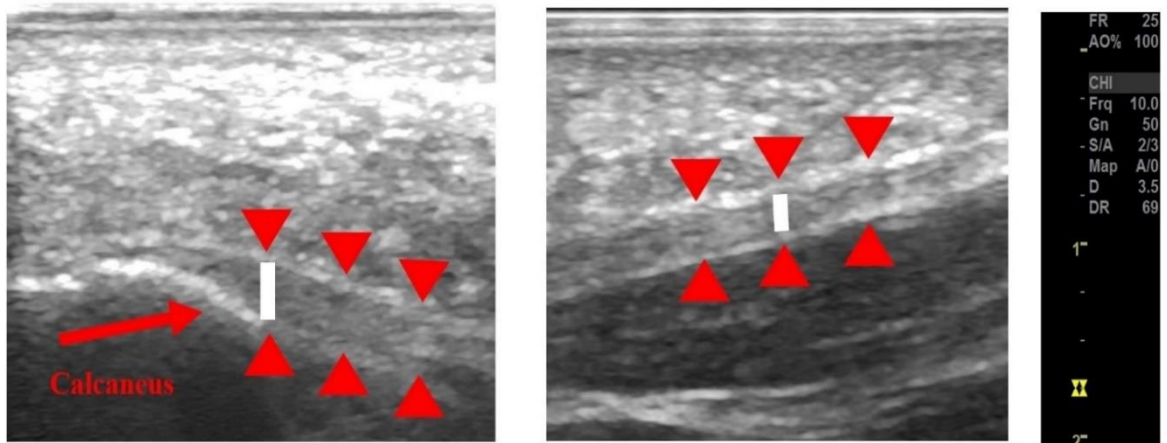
Representation of B-mode ultrasound images to measure PF thickness (white vertical bar) at the proximal (left) and distal (right) sites. The red arrows aid to visualize the trajectory of the PF. The legend on the right displays the image settings and the scale bar in centimeters.
